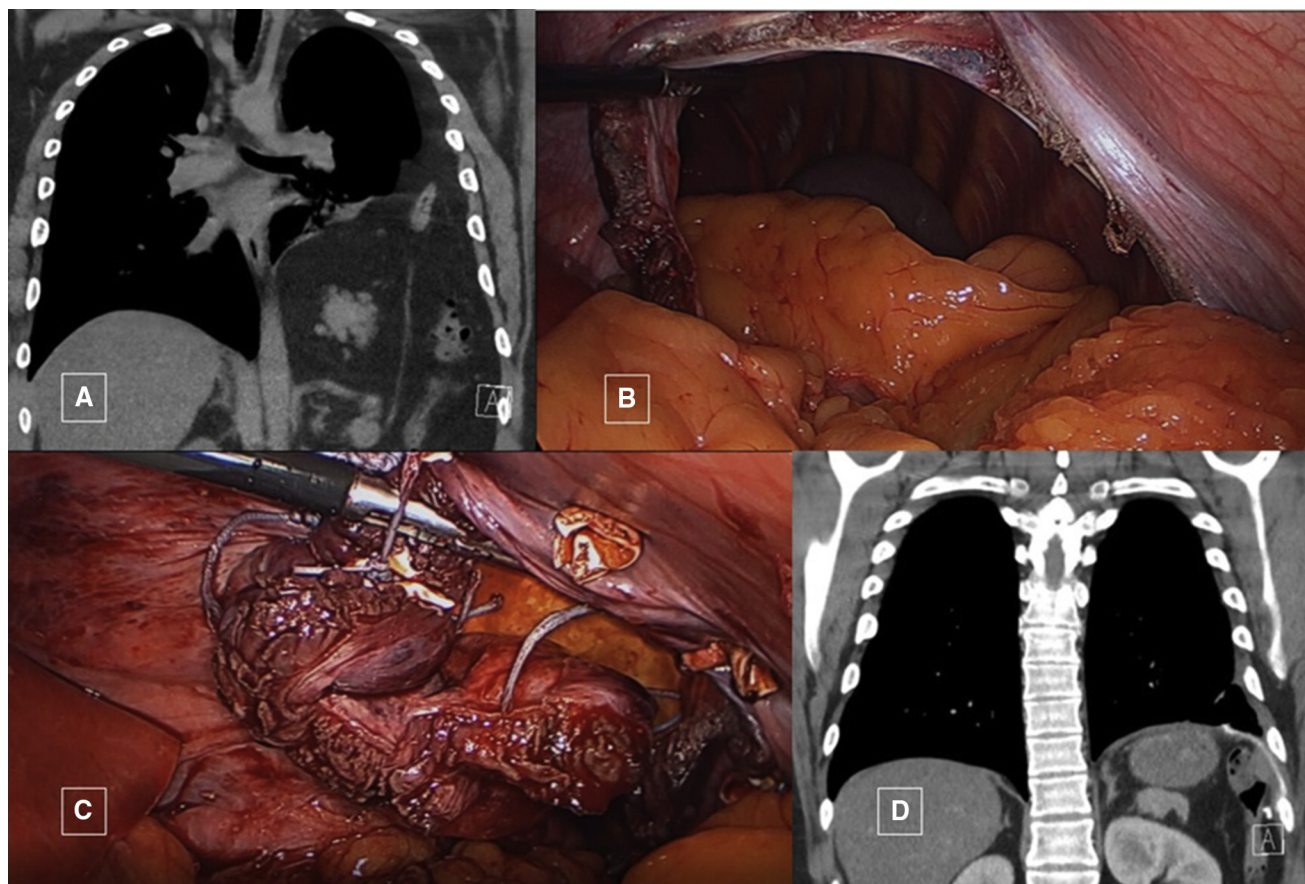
A, Preoperative CT scan. B, Intraoperative laparoscopic view. C, Patch repair. D, Postoperative CT (2 months after repair).
